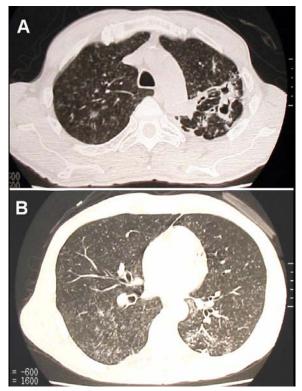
CT showing cavitary lesions and widespread nodular infiltrations at both lungs.
